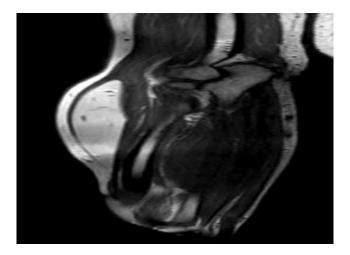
Coronal MRI view of the right forearm showing a hyperintense mass in the right forearm muscle with close proximity to the radial neuromuscular bundle.
